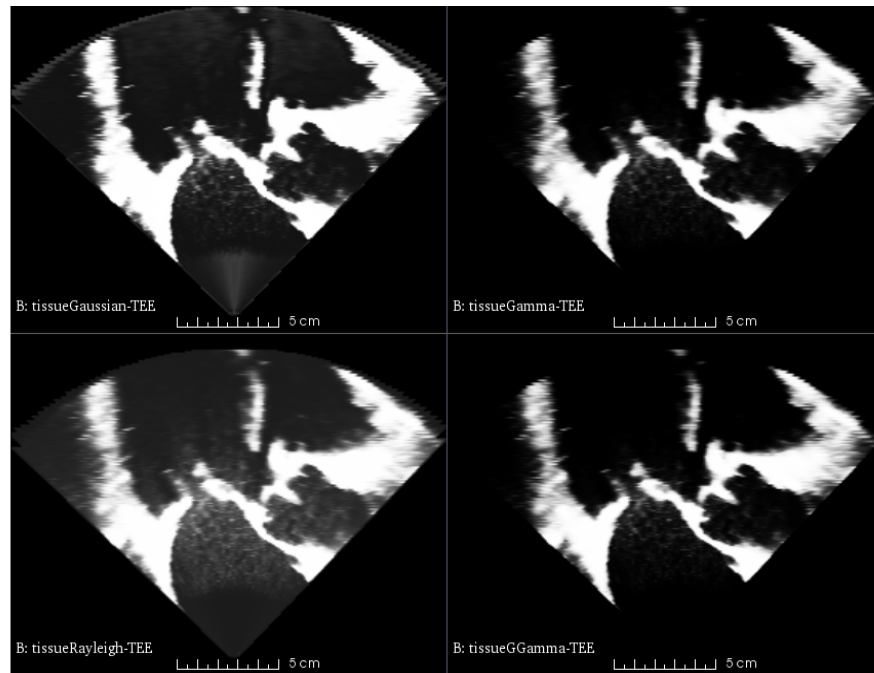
Tissue characterization for the Gaussian, Rayleigh, Gamma and Generalized Gamma Mixture models for the transesophageal echocardiography (TEE).
